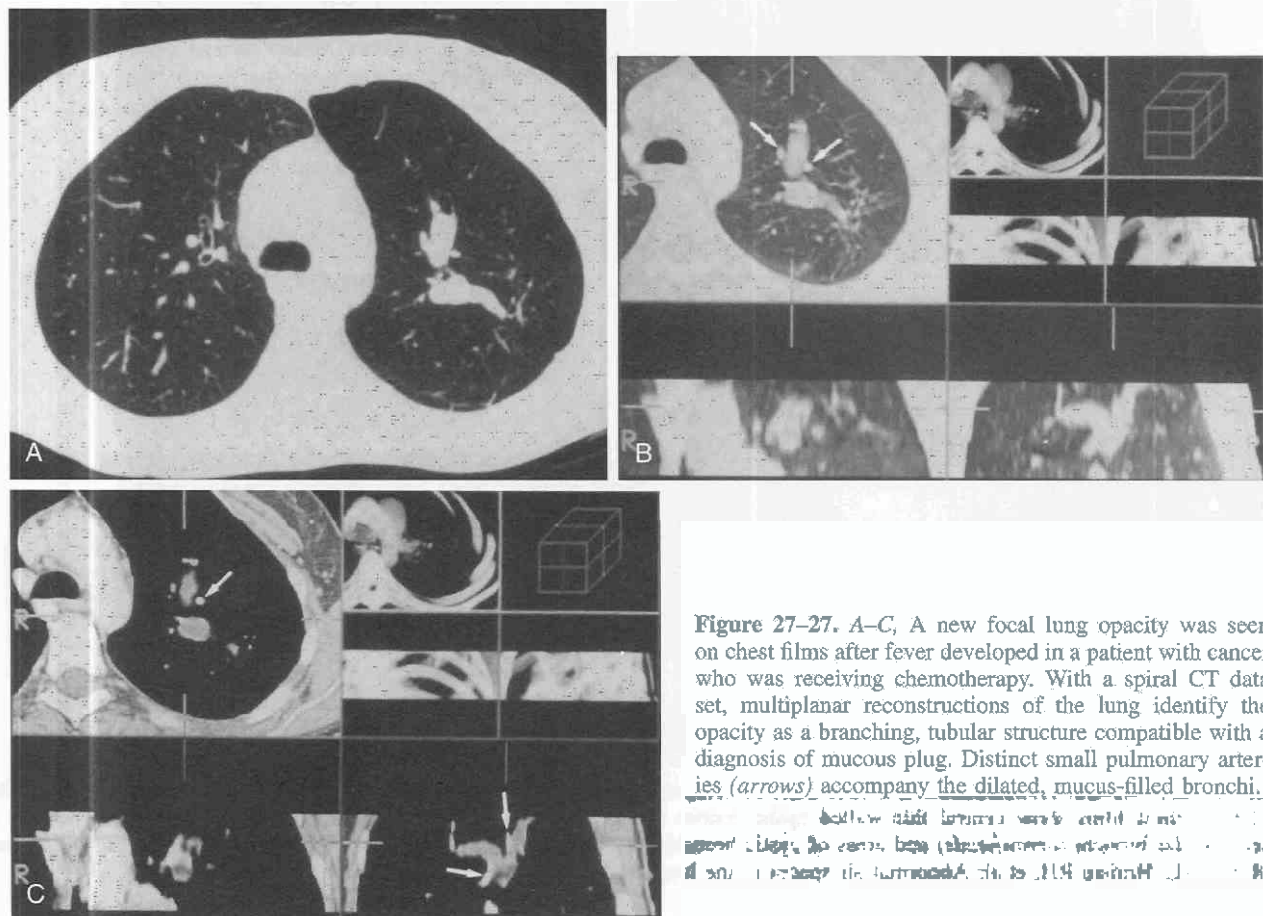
A-C, A new focal lung opacity was seen on chest films after fever developed in a patient with cancer who was receiving chemotherapy. With a spiral CT data set, multiplanar reconstructions of the lung identify the opacity as a branching, tubular structure compatible with a diagnosis of mucous plug. Distinct small pulmonary arteries (*arrows*) accompany the dilated, mucus-filled bronchi.
